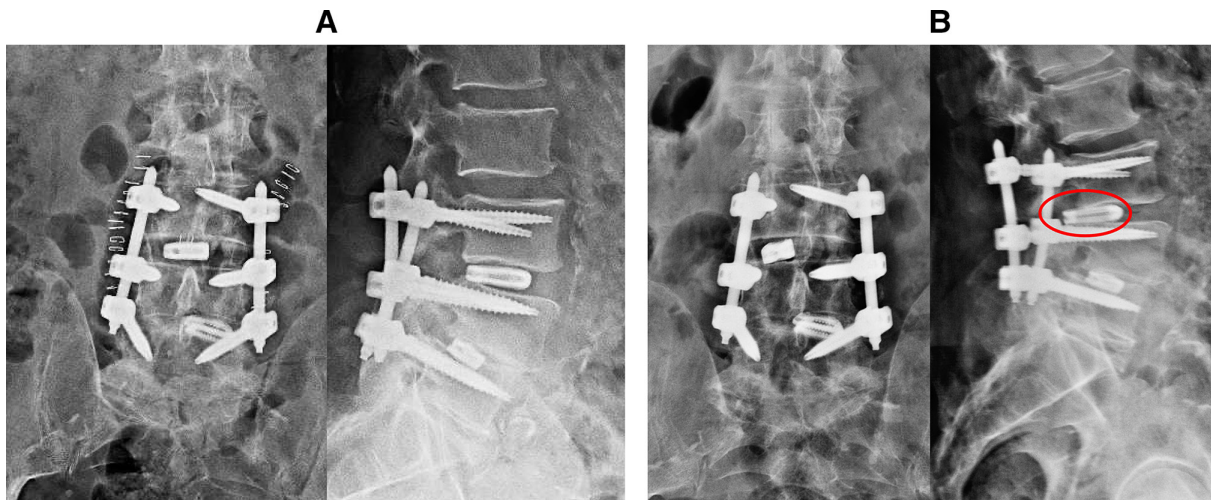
(A) X-ray images of the lumbar spine in anterior/posterior (A/P) (left side) and lateral (right side) views for case 1, 3 mo before he presented to our clinic. Notice the undersized interbody cage at level L3-L4. (B) X-ray images of the lumbar spine in A/P (left side) and lateral (right side) views for case 1 at the time when he presented to our clinic. Also notice the migrated interbody cage into the right neuroforamen at level L3-L4 (marked with a red oval).
